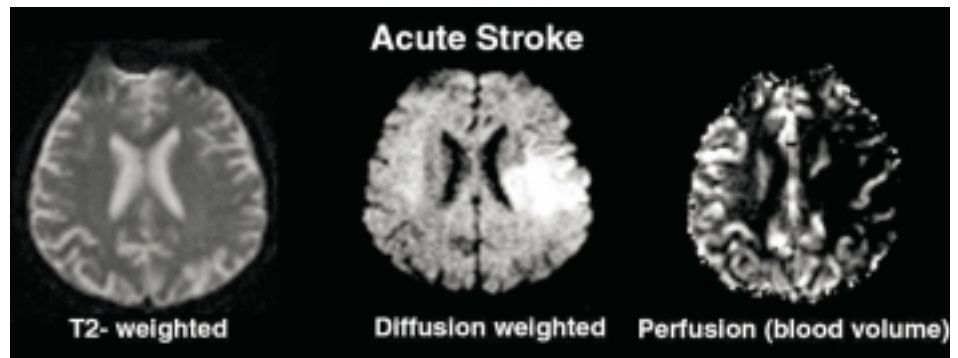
Three different MRI imaging protocols of a patient 20 min after a stroke event. The T2 weighted image in the first panel shows some structural information about the patient's brain but no evidence of the site of the stroke. The diffusion weighted image, which monitors the random movement of water, shows a distinct lesion on the right side of the patient (right side of middle panel). This is representative of decreased water diffusion in the area of the stroke, where there are dead neurons. The third panel shows a perfusion image, which demonstrates regions of the brain where there is reduced blood flow. The region of reduced blood flow in this patient (dark areas) is identifiable by the lower contrast and structural detail. This is larger than the area highlighted in the diffusion-weighted image, which may indicate that there may be additional neuronal cell loss. Courtesy of Drs. Steven Warach and Lawrence Lautor, National Institutes of Neurological Disorders and Stroke, National Institutes of Health, MD.
